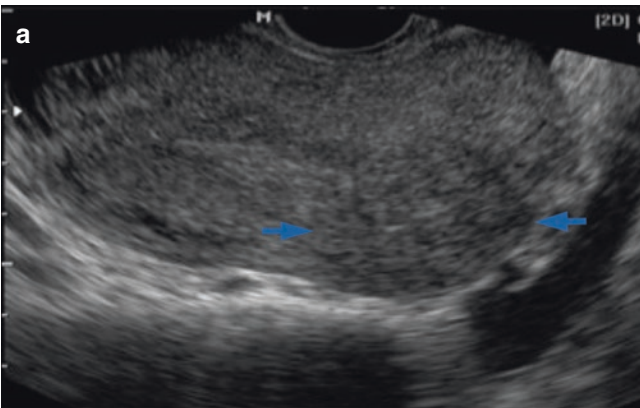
Transvaginal oblique image of the uterus. (a) Grayscale shows adenomyoma on the fundus (arrows). (b) Color Doppler sonogram of the same image shows the presence of straight vessels traversing a hyper-trophic myometrium
